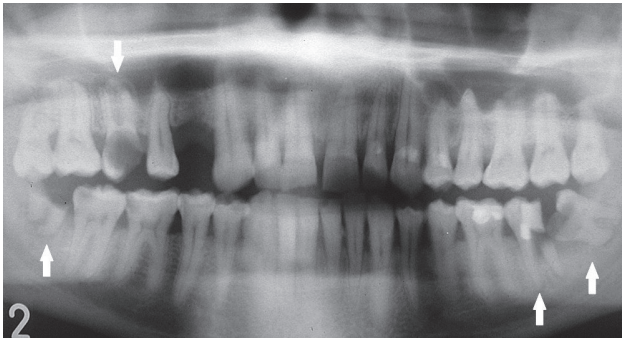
Panoramic radiograph of the dentition of an HIV-positive younger individual. Note posterior teeth 16, 37, 38, 48 (arrows) fully destroyed by dental decay and indicated for extractions.
